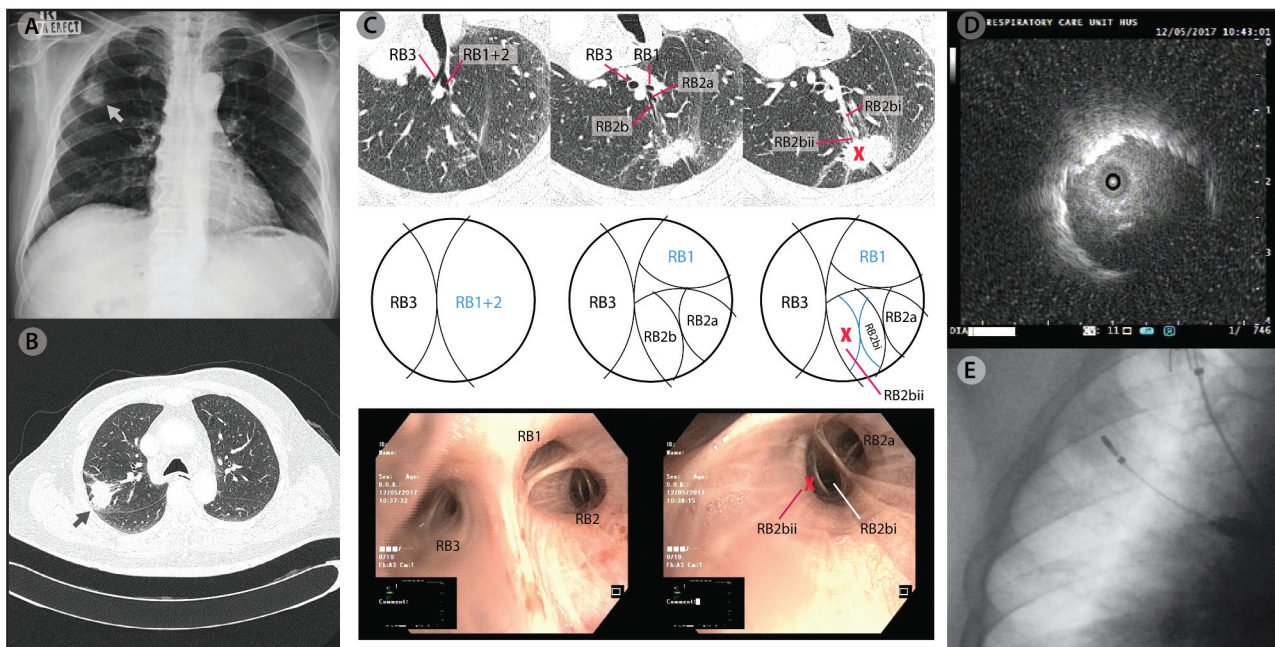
(A) Chest radiograph demonstrating a right upper lobe nodule (arrow).
